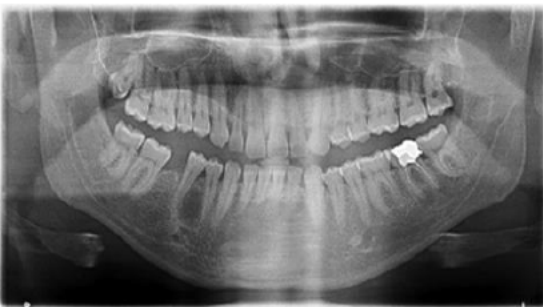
An orthopantomograph showing an apparent radiolucency with sclerotic margins between mandibular right premolars.
